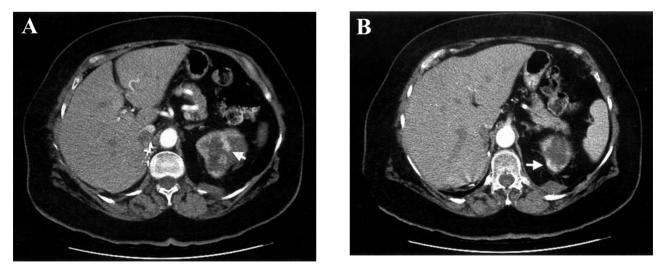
Contrast-enhanced CT scan obtained after first radiofrequency ablation session. The left renal tumor reveals residual enhancement (arrow) in the central (A) and peripheral (B) areas. Necrosis from the prior RF treatment extends medially and laterally. There is a post treatment hematoma in left posterior pararenal space.
